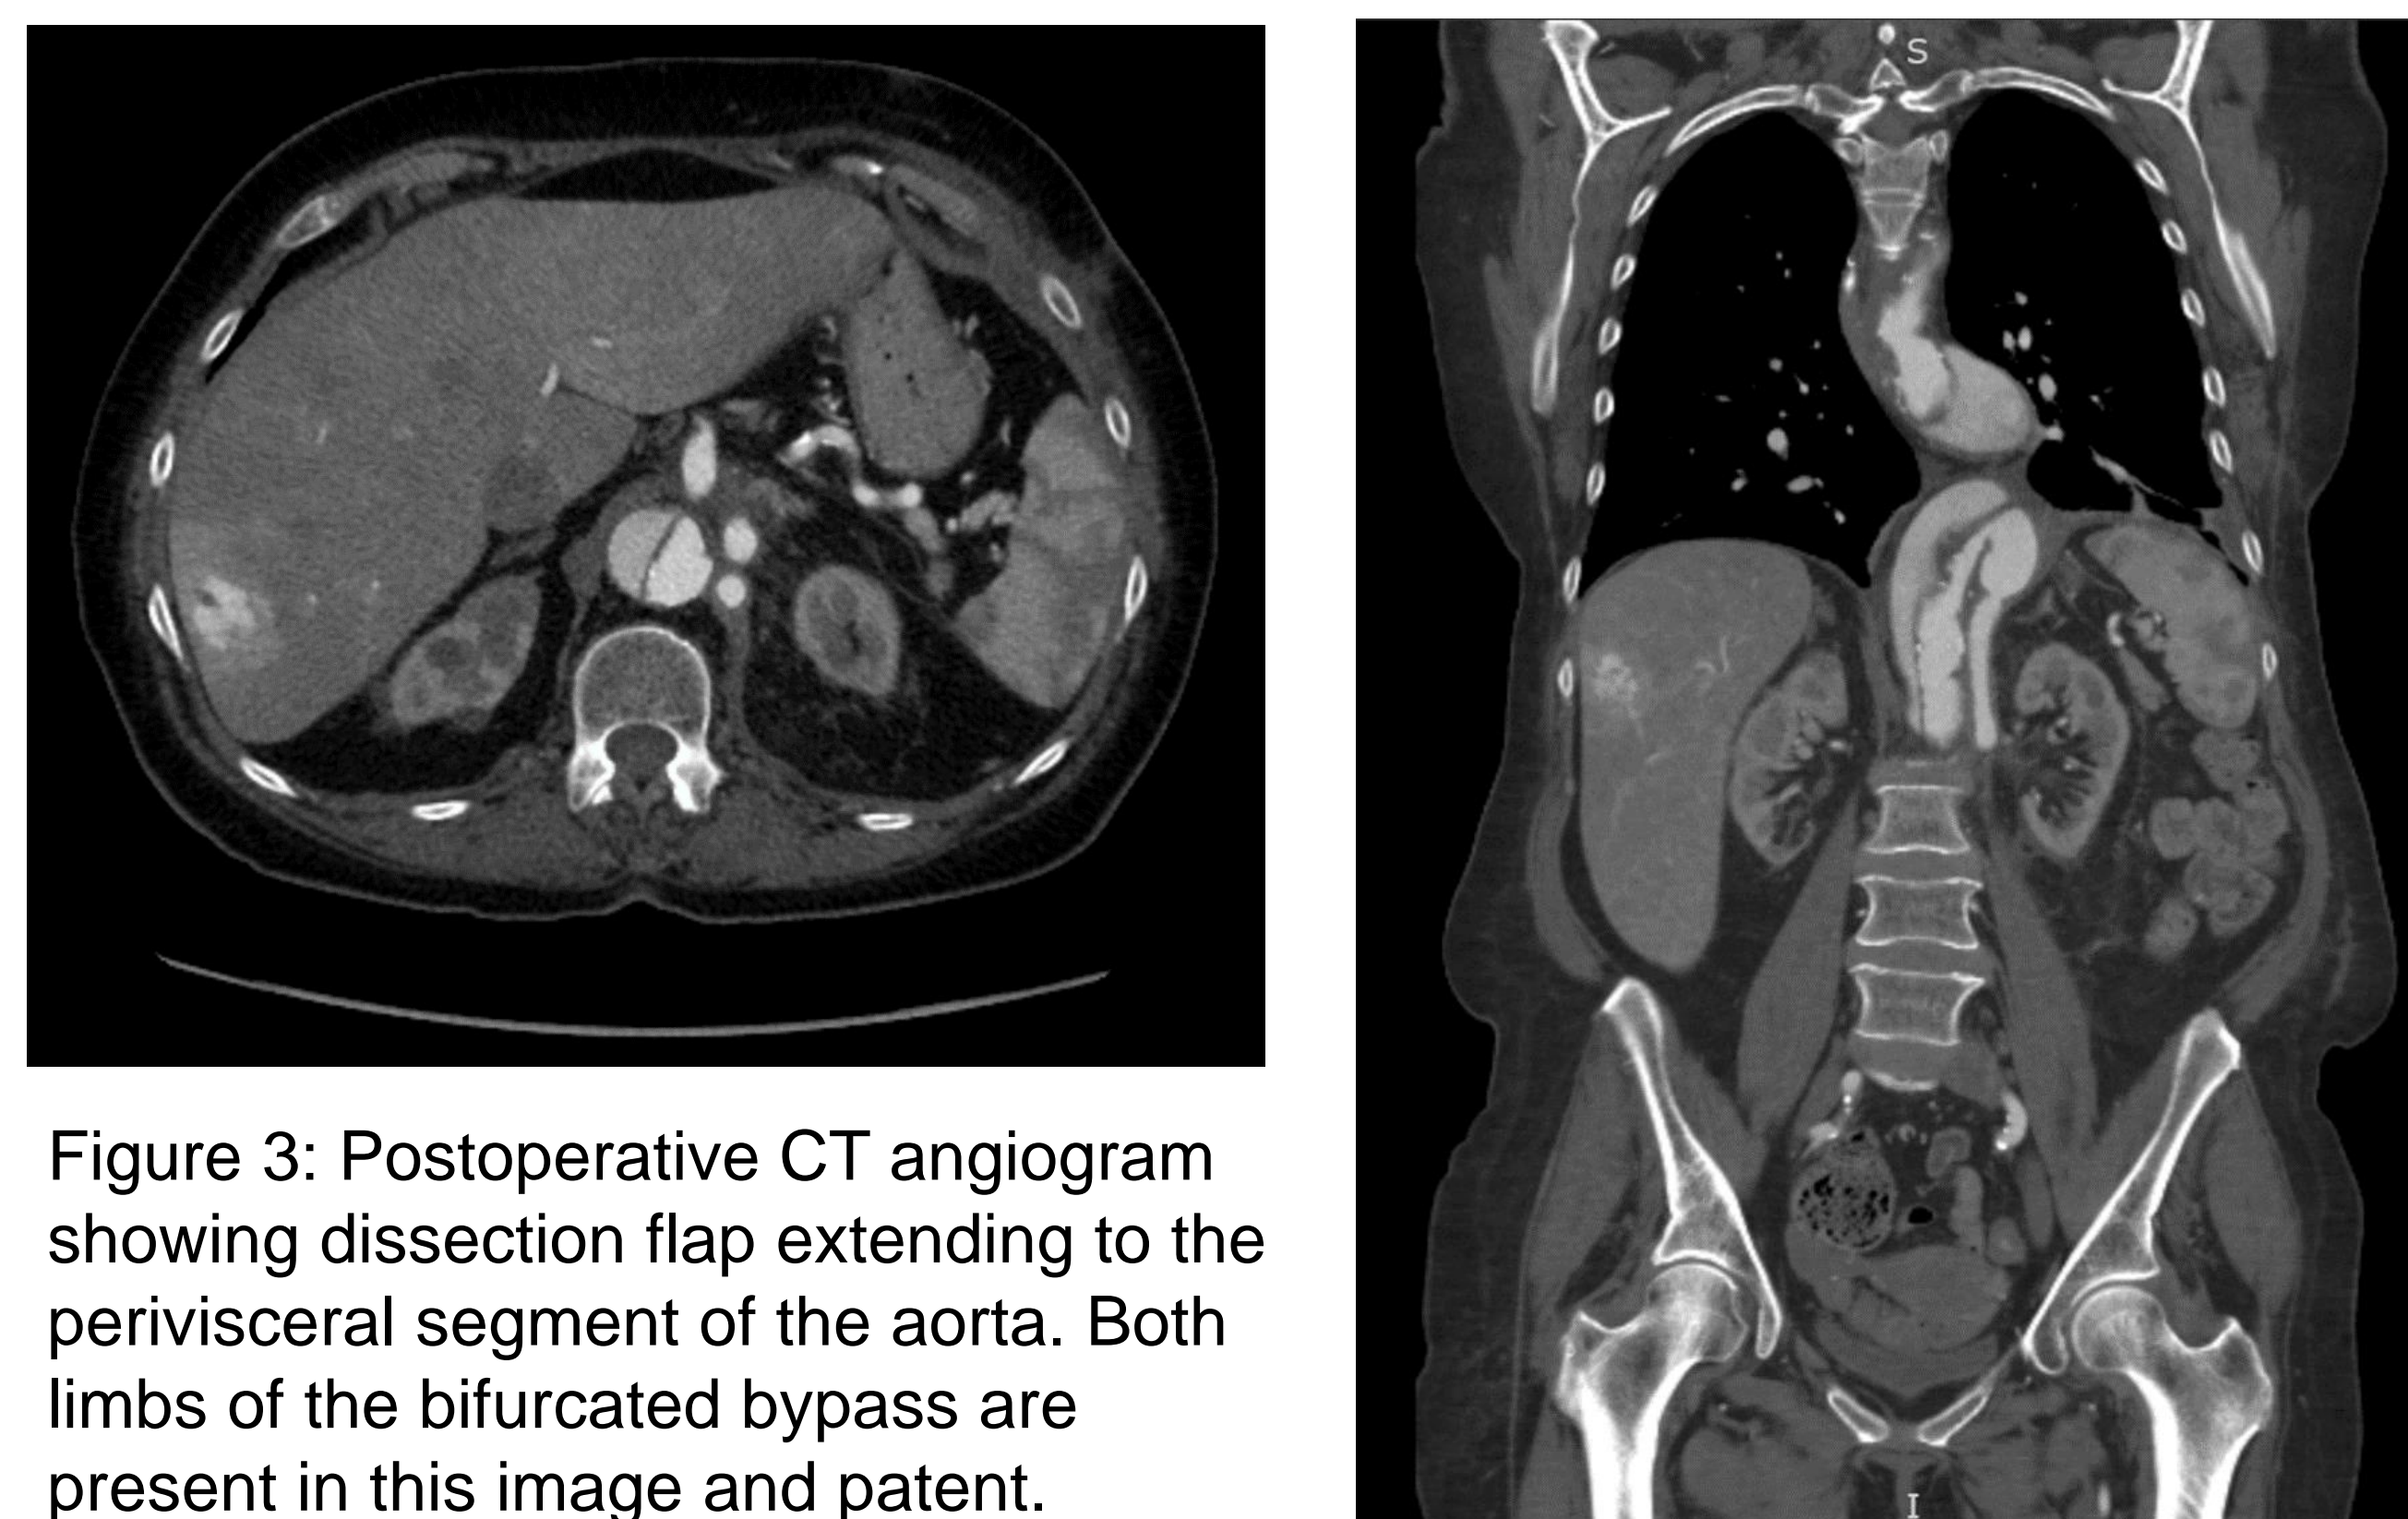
Postoperative CT angiogram showing dissection flap extending to the perivisceral segment of the aorta. Both limbs of the bifurcated bypass are present in this image and patent.
